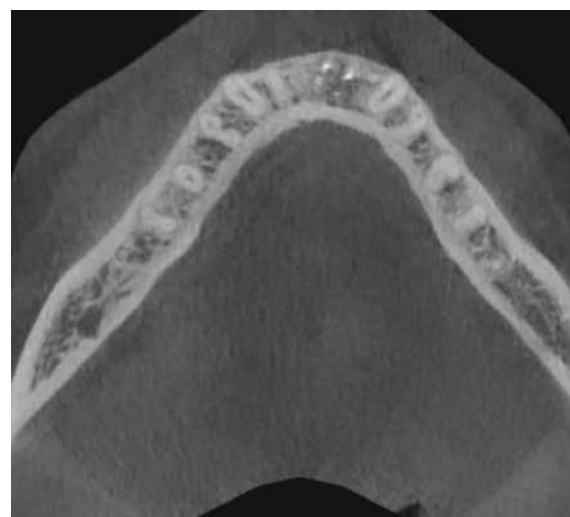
CBCT axial view demonstrating at 6 months the facial contours restored by osseous grafting of the large defect with Bond Apatite®.
